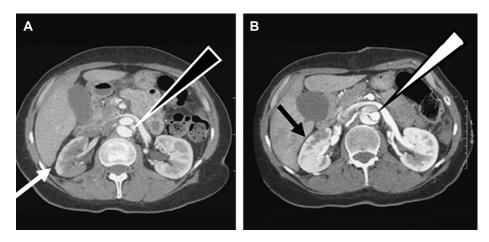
Coronal CT images (A) demonstrating right renal malperfusion (white arrow) and compressed true lumen (black filled triangle) preoperatively. Scan (B) shows the post-stent scan demonstrating improved right renal perfusion (black arrow) and dominant flow in a somewhat larger true lumen (white filled triangle). Note the post-stent hypoenhancement in the false lumen.
